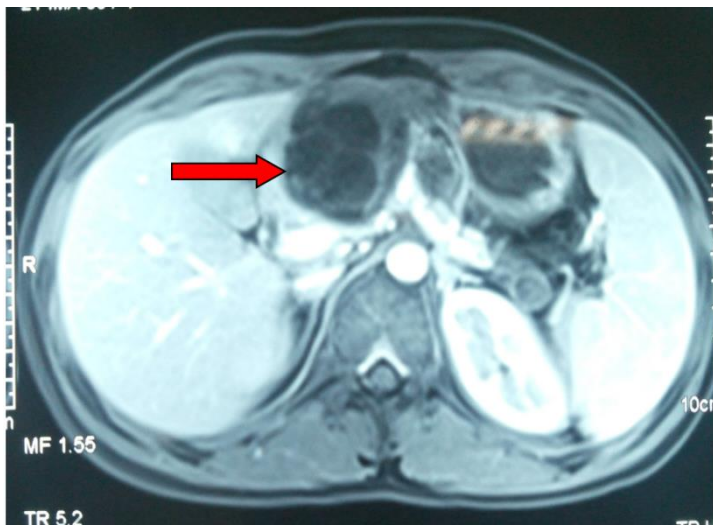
Magnetic resonance imaging of the hydatid cyst occupying the body of the pancreas
